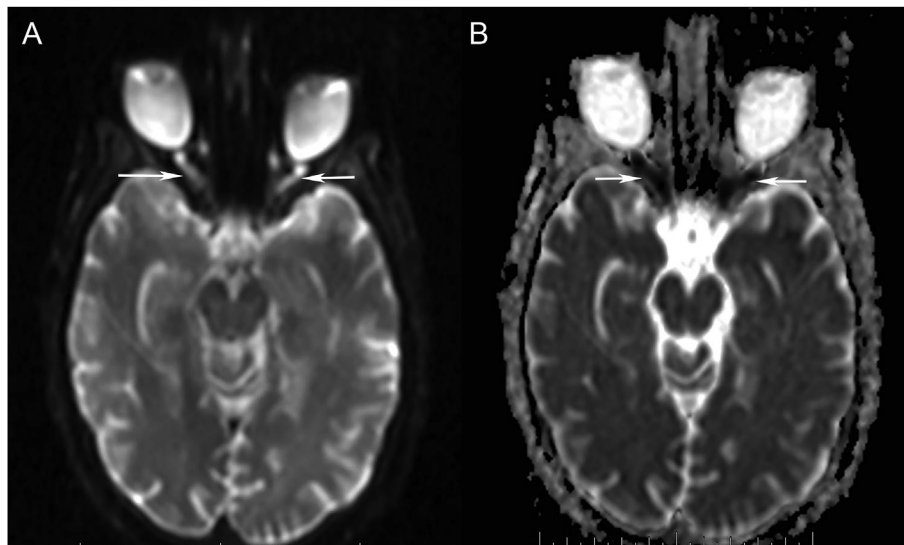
A. Diffusion-weighted (DWI) orbital magnetic resonance imaging (MRI), axial view, showing bright signal for the entire length of the intraorbital optic nerves (arrows), consistent with restricted diffusion of ischemia. B. Apparent diffusion coefficient (ADC) image, showing dark signal for the entire length of the intraorbital optic nerves (arrows), confirming restricted diffusion of ischemia.
